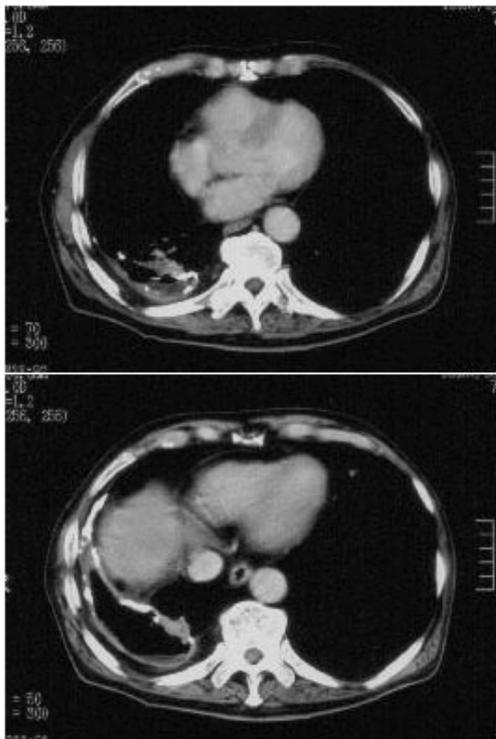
Enhanced chest CT performed after 8 courses of CHOP therapy revealed that the mass had almost disappeared.
